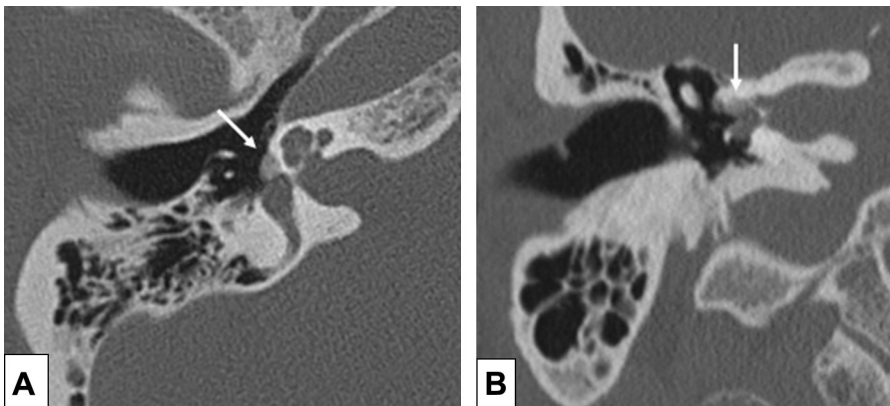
Fenestral otosclerosis. Axial (A) and coronal (B) HRCT images of active, spongiotic stage of otosclerosis (*arrow*) with demineralization of the fissula ante fenestram, anterior to the oval window. (Courtesy of Simon Angeli, MD, Rita Ghose Bhatia, MD, University of Miami, Miami, FL)
